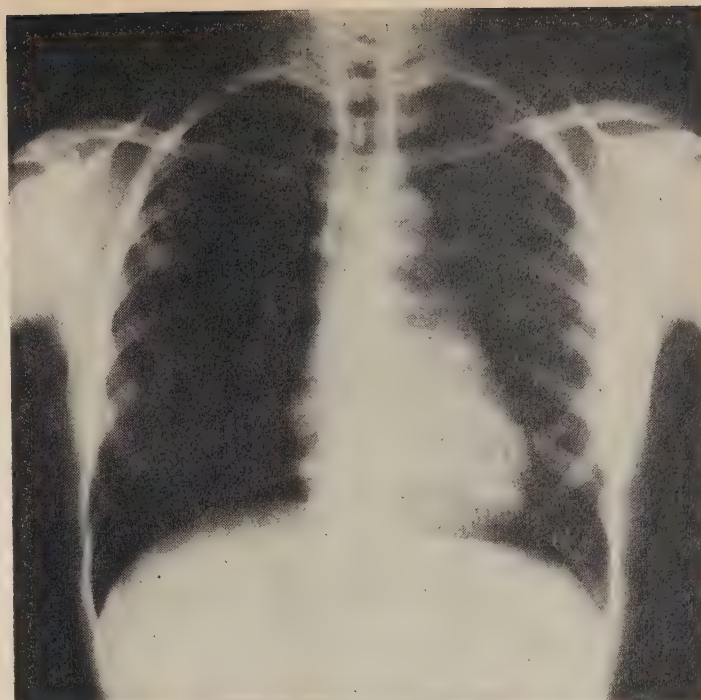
Chest radiograph shows patchy areas of infiltration and suspicious radiolucent areas.
